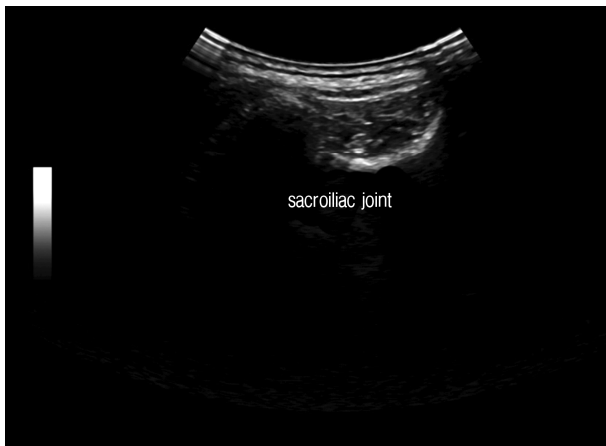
sacroiliac joint (dorsal SI ligament & interosseous ligament) as target point of prolotherapy on ultrasonography.
